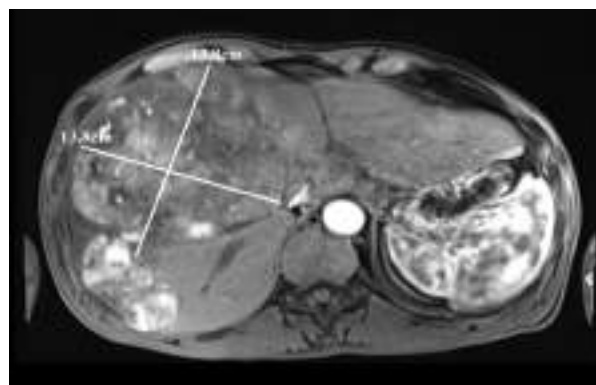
Abdominal MRI after sixth cycles of sorafenib therapy (June 2020)
